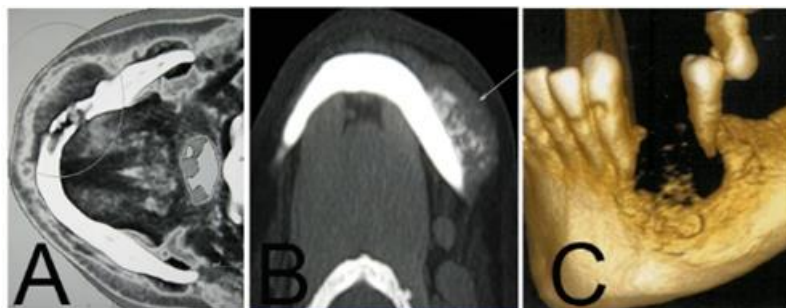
Contrast-enhanced jaw CT. A. Axial reconstruction, in which the mandibular bone structure and adjacent soft tissues are compromised. B. Axial reconstruction with a lesion on the left side, with a “sunshine” appearance by the formed osteoid tissue. C. 3D reconstruction, in buccal view from the left side, with bone destruction involving teeth 33 and 35.
